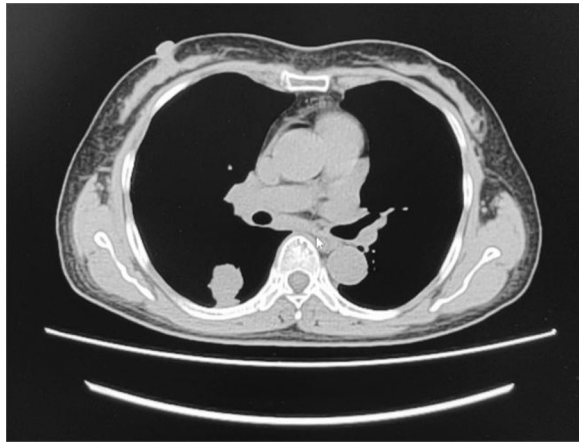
Computed tomography showing right lung mass
